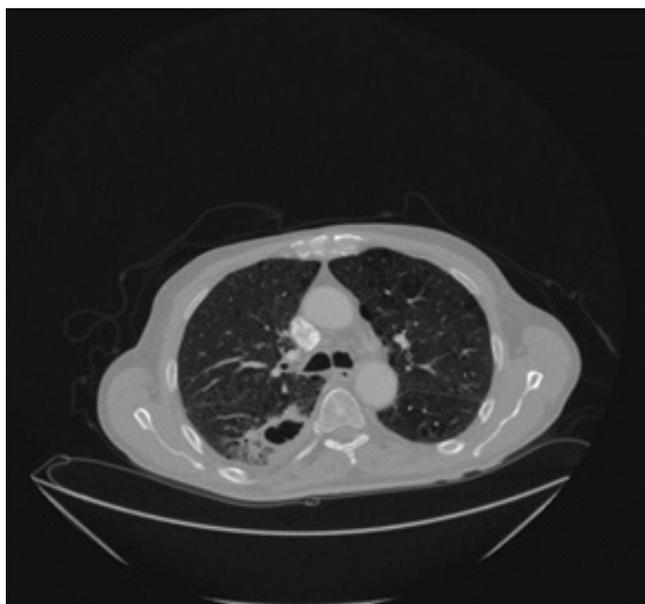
Contrast- enhanced transverse CT scan of the chest shows peripherally located cavitated mass in the superior lower lobe segment on the right side.
